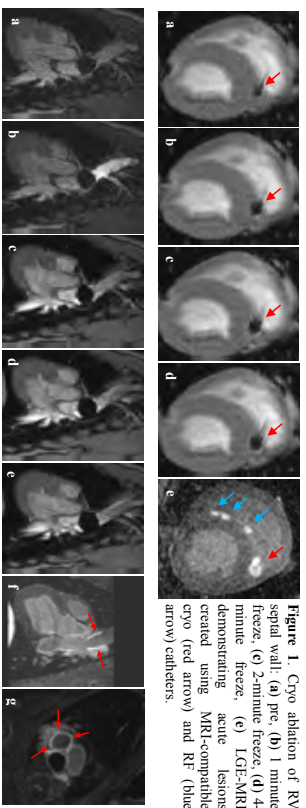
Cryo ablation of RV septal wall: (a) pre, (b) 1 minute freeze, (c) 2 minute freeze, (d) 4 minute freeze. (e) LGE-MRI demonstrating acute lesions created using MRI-compatible cryo (red arrow) and RF (blue arrow) catheters. (f) sagittal and (g) axial views. Red arrows indicate circumferential ablation with no gaps at SVC-RA junction.
